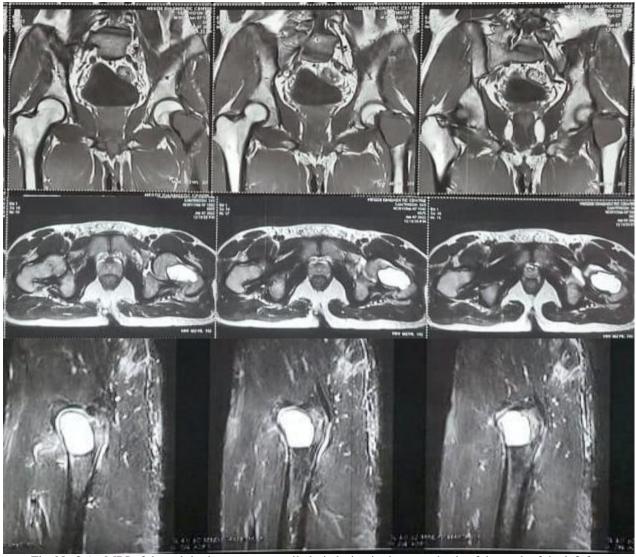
An MRI of the pelvis shows an expansile lytic lesion in the metaphysis of the neck of the left femur.
